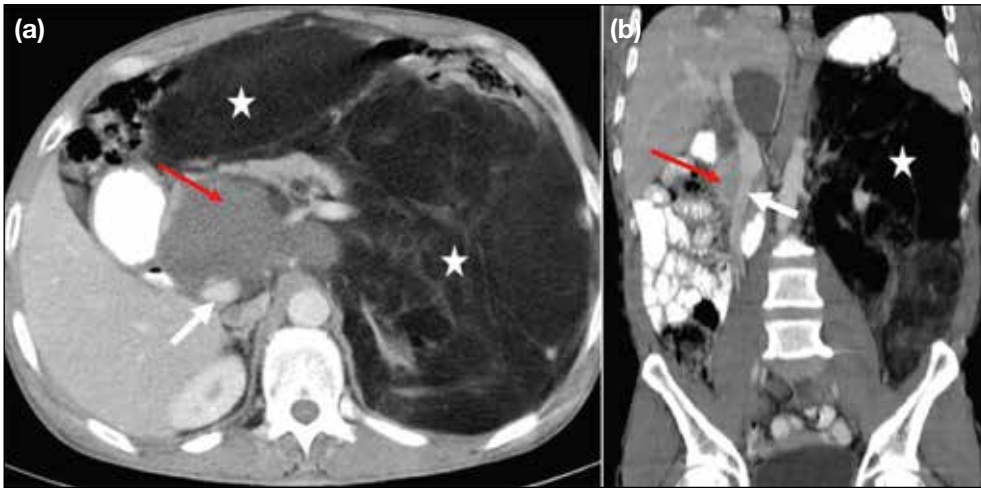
Retroperitoneal liposarcoma. (a) Axial and (b) coronal contrast-enhanced computed tomography images of the abdomen show large fatty component (stars) and small soft-tissue component (red arrows) encasing the inferior vena cava (white arrows).
